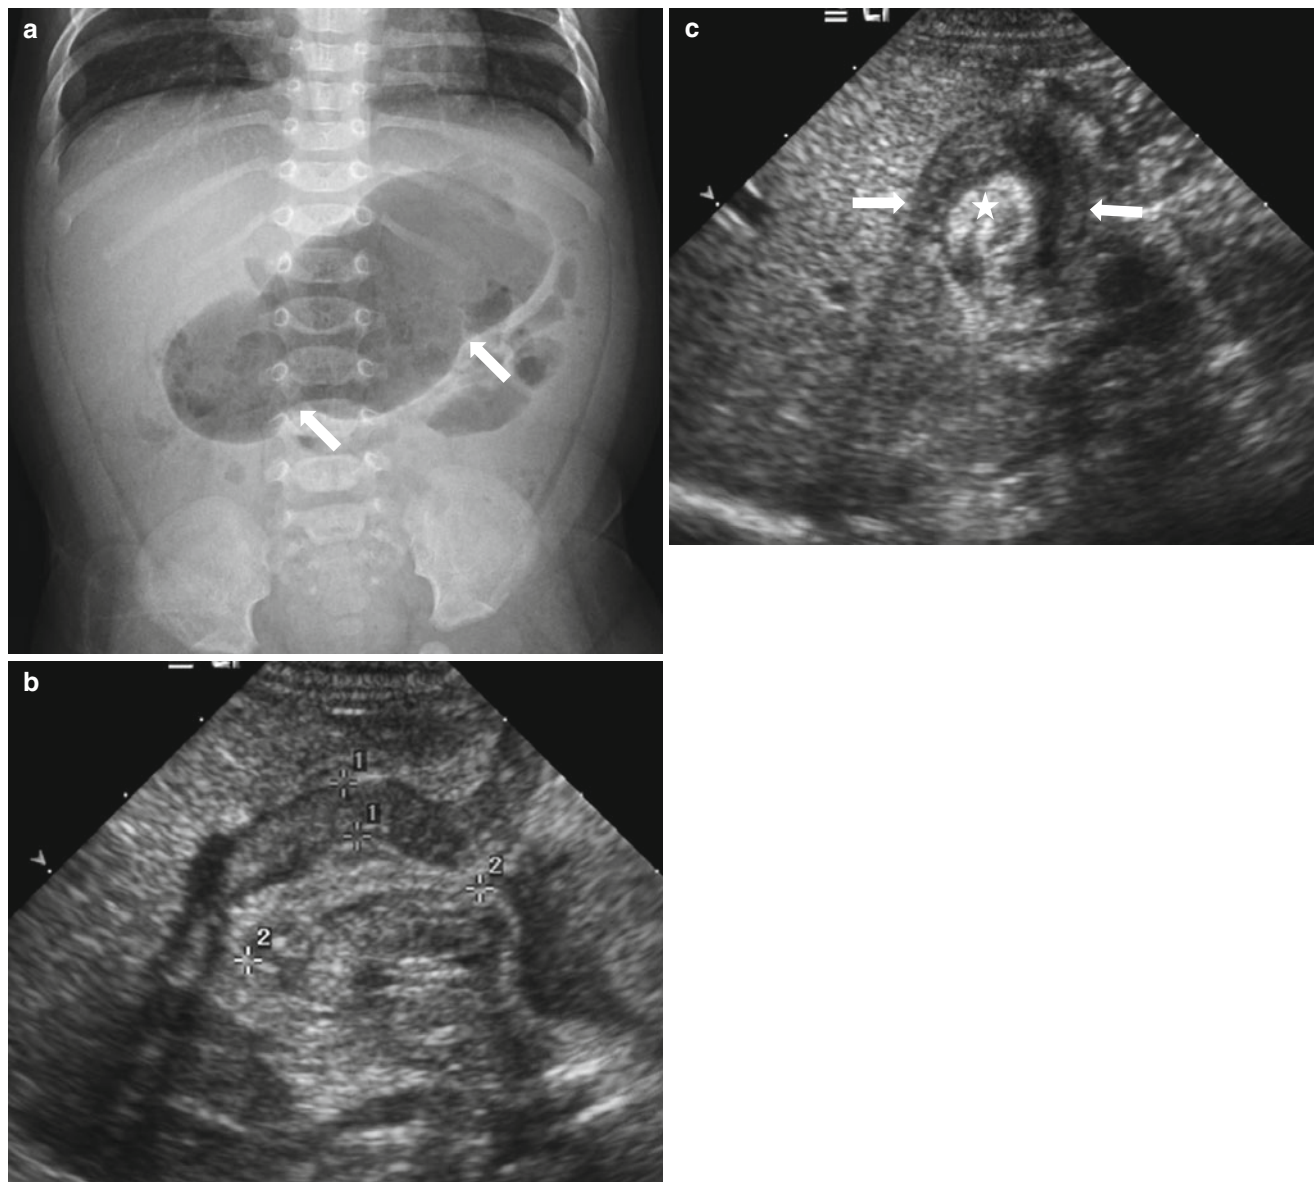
Hypertrophic pyloric stenosis in an 8-week-old infant with vomiting. (a) Supine abdominal radiograph shows gaseous distension of the stomach with prominent peristaltic waves (arrows), called “caterpillar sign.” There is a paucity of distal bowel gas. (b, c) US images in longitudinal and transverse scan of the pylorus demonstrate
